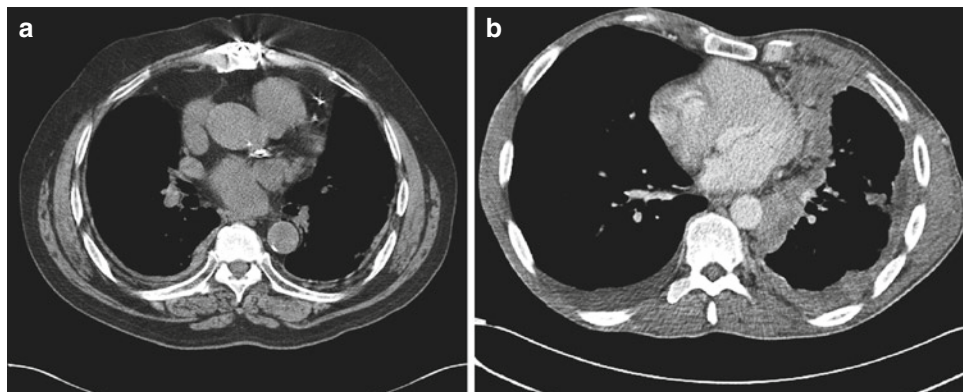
(a, b) Benign and malignant pleural thickening on CT scan
